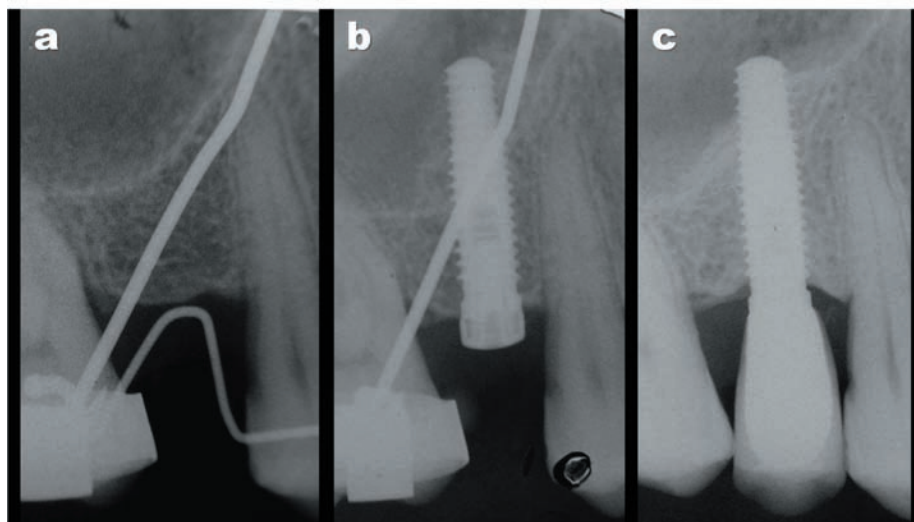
Radiographic aspect of the surgical area (a) previously, (b) immediately after, and (c) 2 years after the surgical procedure. The images suggest that there was bone remodeling between the surgery session and 2 years later.
